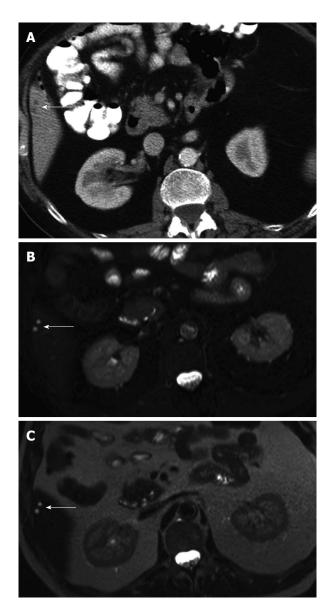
Example of a small lesion which proved to be benign after follow-up. A: Two small (< 10 mm) indeterminate focal liver lesions (white arrow) on contrast-enhanced computed tomography; B: Corresponding magnetic resonance imaging (MRI), images showing a T2w Turbo Spin Echo sequence with fat suppression. Two clearly hyperintense focal liver lesions (white arrow) are displayed compatible with simple liver cysts; C: Corresponding MRI images showing a T2w Turbo Spin Echo sequence without fat suppression. Two clearly hyperintense focal liver lesions. Two clearly hyperintense focal liver lesions (white arrow) are displayed compatible with simple liver cysts;
